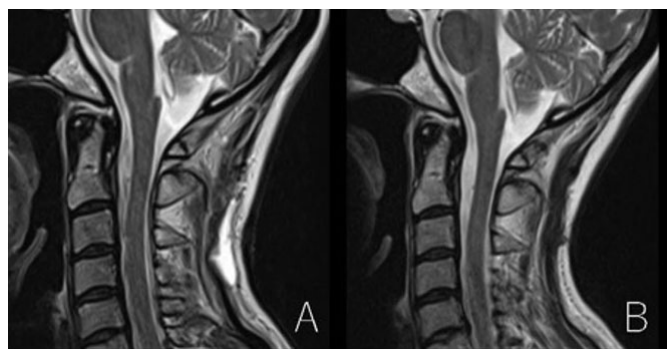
Follow-up MRI. (A) Sagittal T2-weighted image after surgery. (B) Sagittal T2-weighted image at three months after surgery.
